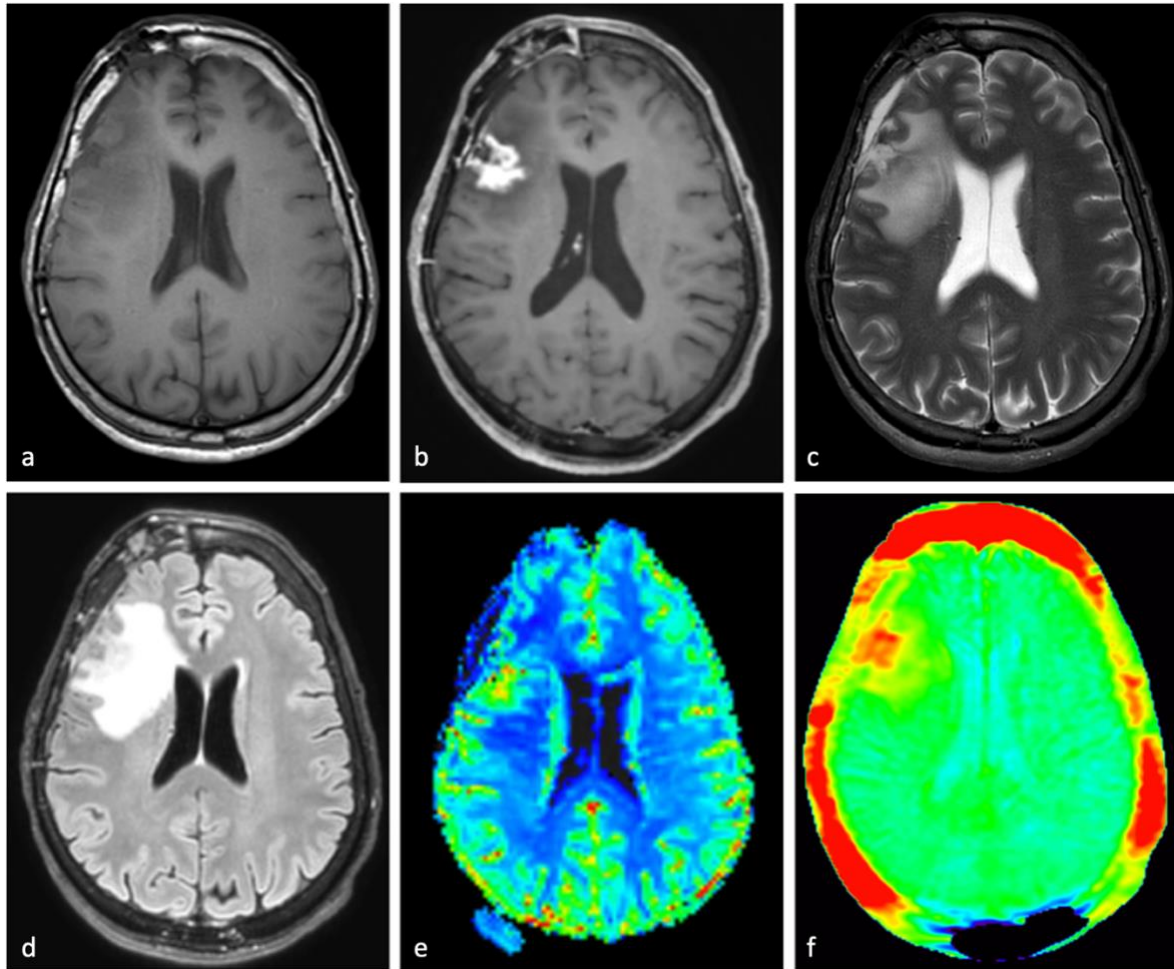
MR images of patient 2, who has a glioblastoma IDH-wildtype (WHO grade 4). a. T1-w image. b. Gd-T1w image. c. T2-w image. d. T2-FLAIR image. e. DSC perfusion study. f. APT-w image.
